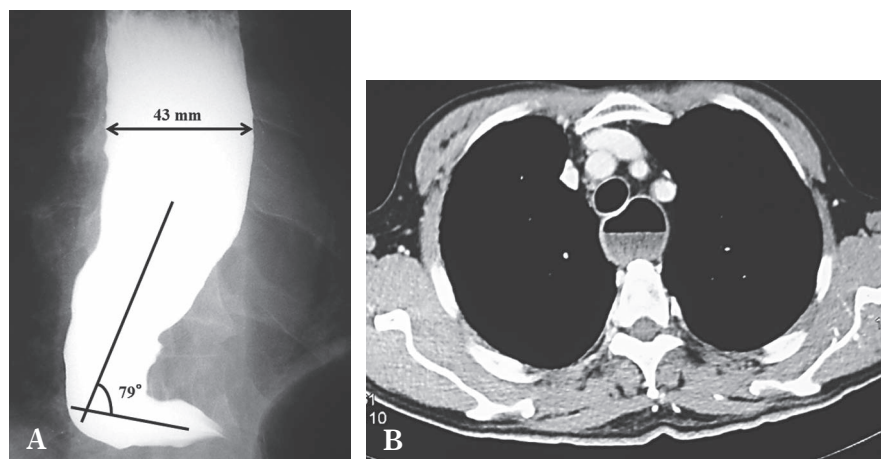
A : Advanced sigmoid-type achalasia is seen at an angle of 79 degrees with a maximal transverse diameter of 43 mm. B : Computed tomography of the chest demonstrates fluid in the esophagus.
